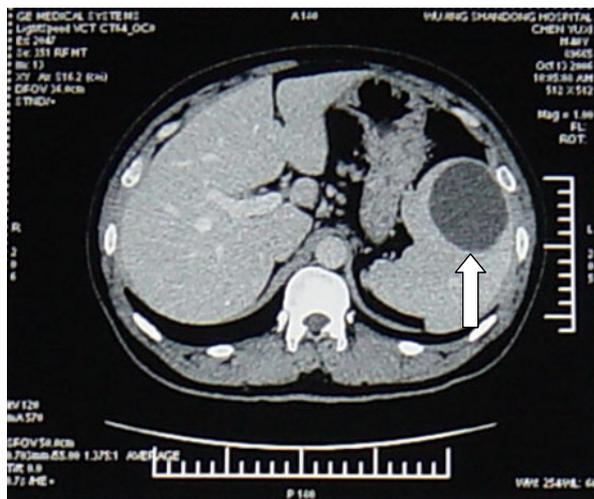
Case 1, CT showed a 7cm × 8cm × 6cm low-density mass on the upper pole of the spleen (arrow)
